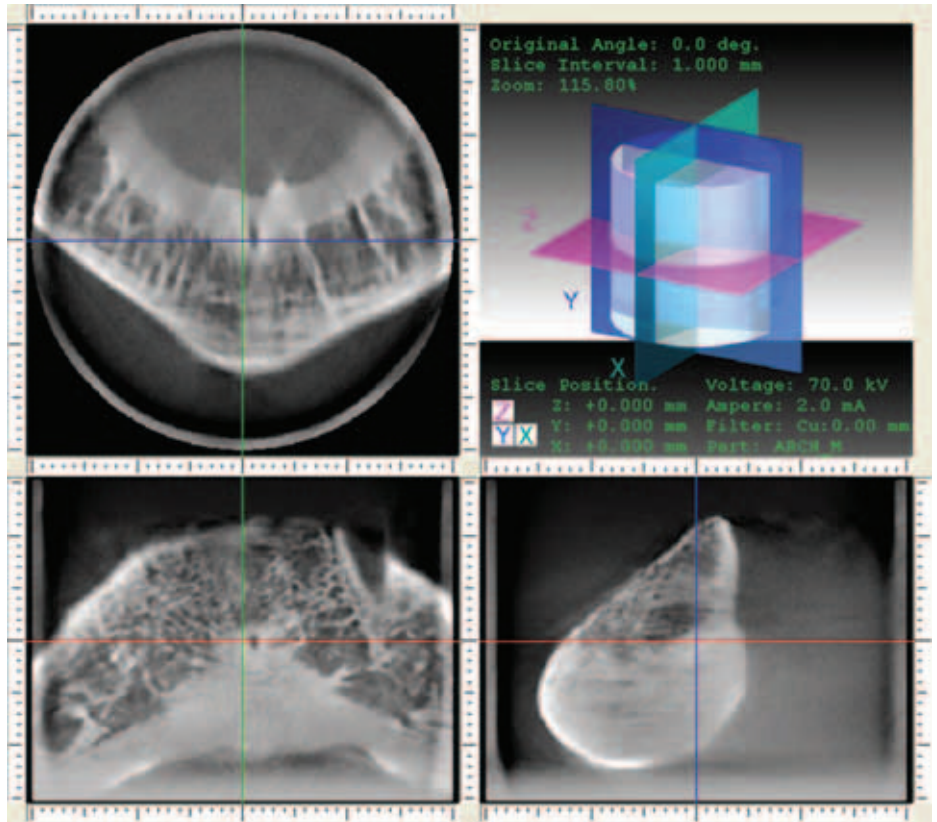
Cone-beam CT examination of the anterior mandible, showing the coronal, axial and sagittal images produced by this technique. Image courtesy of Reinhilde Jacobs, Paulo Couto and Livia Corpas, Oral Imaging Center, KU Leuven.
